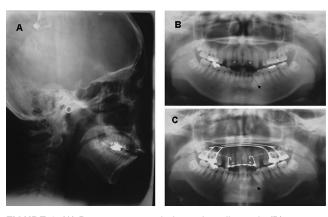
(A) Pretreatment cephalometric radiograph; (B) pretreatment panoramic radiograph with multiple odontoma present; and (C) after multiple odontoma removal.
